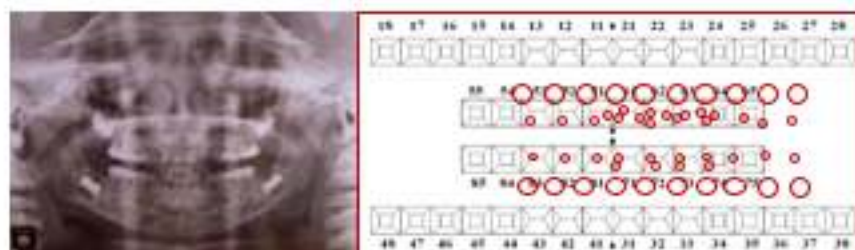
(A) Panoramic X-rays That Shows Abnormalities Enamel Hypoplasia; (B) Odontogram Enamel Hypoplasia.
